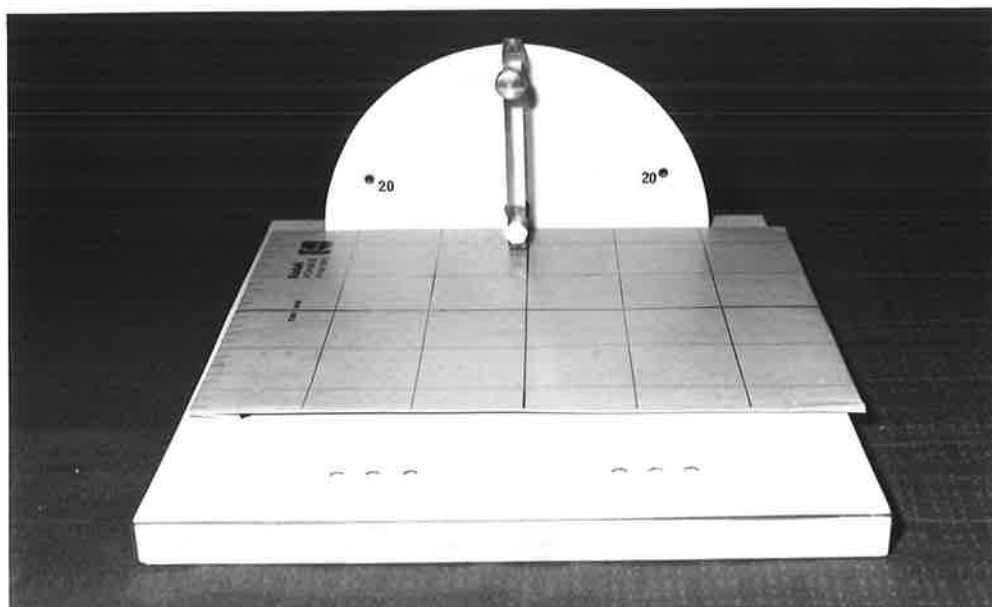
Apparatus used in radiographic measurement of movement at the T-M1 joint.
